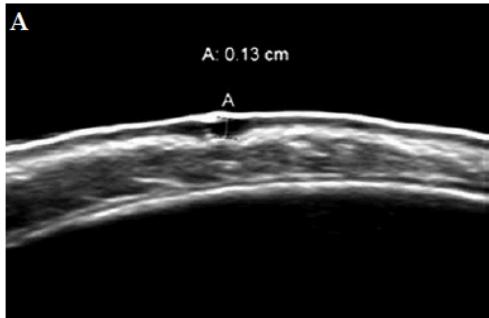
High frequency ultrasonography examples of depth measurement. A) Superficial basal cell carcinoma. B) Nodular basal cell carcinoma
